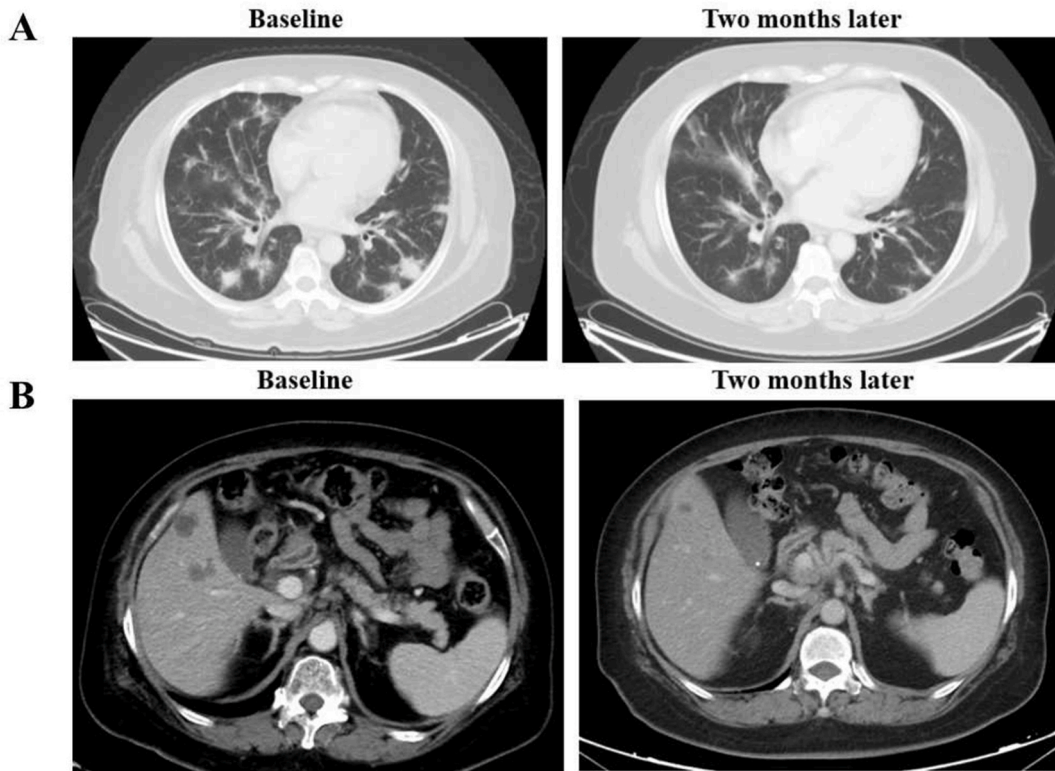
Clinical response of pembrolizumab and seliprecatinib for the case with *RET* fusion and PD-L1 over-expression. A: CT scan revealing the clinical response to pembrolizumab. B: CT scan revealing the clinical response to seliprecatinib. Abbreviations: PD-L1: programmed cell death ligand 1; *RET*: rearranged during transfection; CT: computed tomography.
